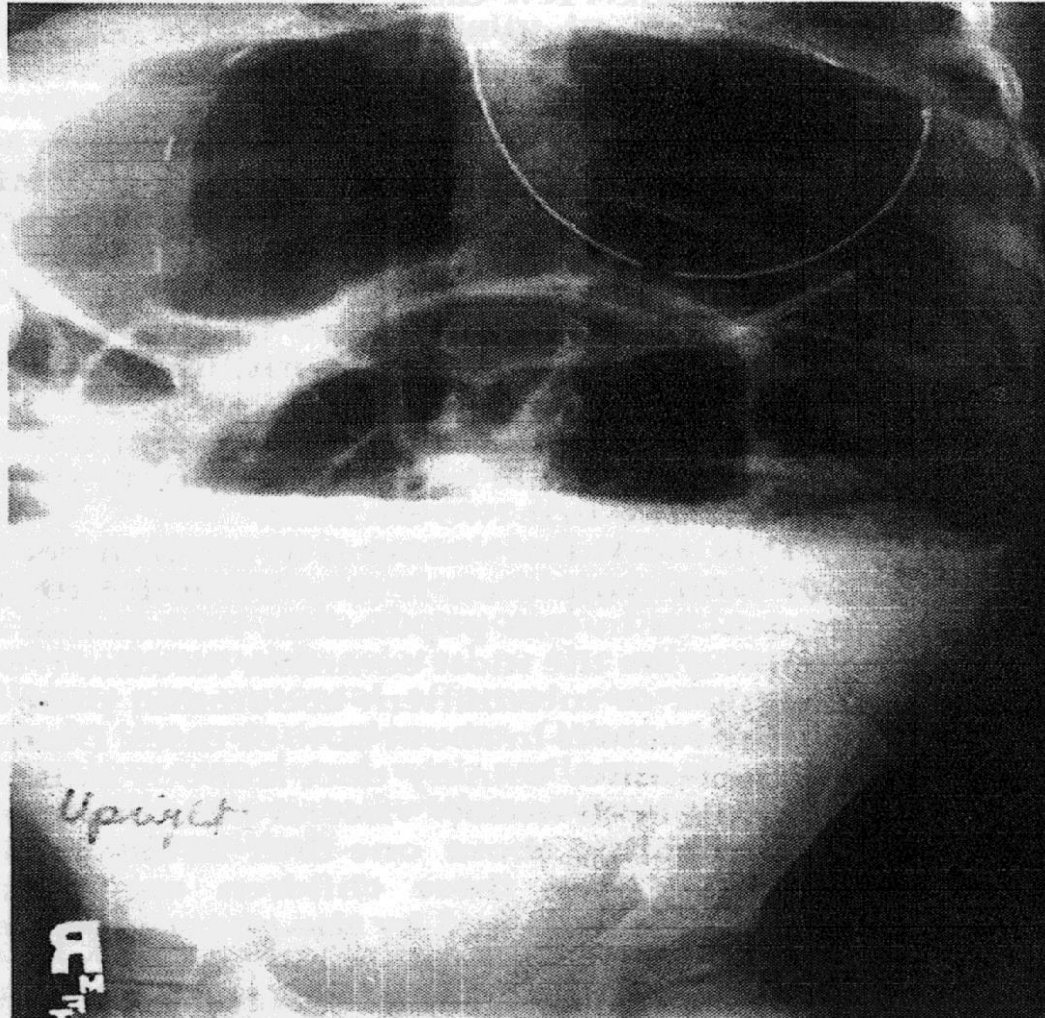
Upright abdominal radiograph in a 4-year-old boy with hollow visceral myopathy. Note bowel dilatation and air-fluid levels, catheter in the inferior vena cava and antroduodenal manometry catheter in the stomach and duodenum.
